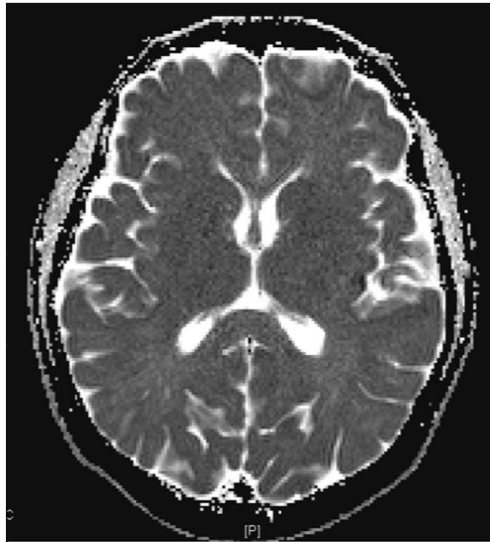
Brain diffusion weighted (DWI) MRI (a) showed bilateral, especially left occipital, frontal cortical white matter and splenium of corpus callosum diffusion restriction, (b) Apparent Diffusion Coefficient (ADC) showed reduced ADC values due to vasogenic edema and FLAIR sequences (c) showed hiperintensities in the same localizations.
